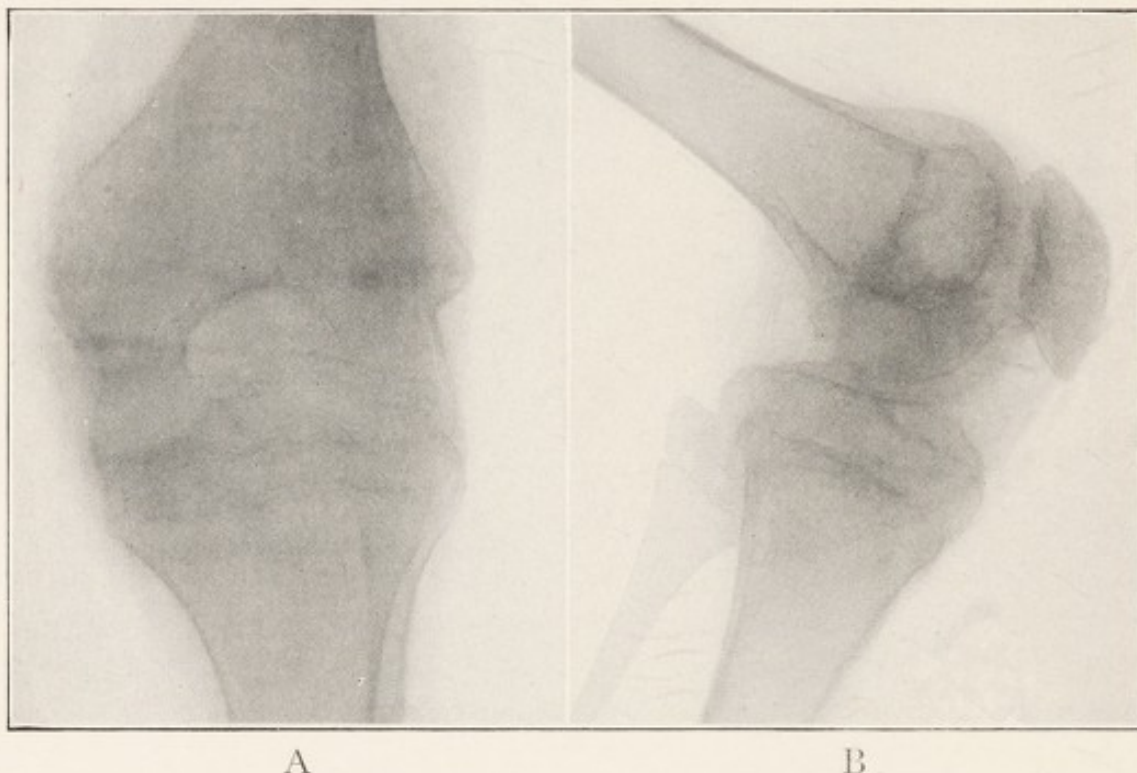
X-RAY SHOWING TUBERCULOSIS OF KNEE, LATE STAGE, ANTERO-POSTERIOR VIEW.
